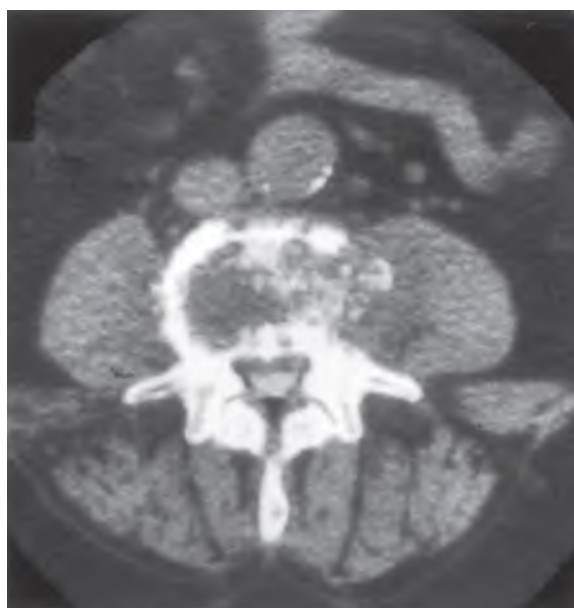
Radiograph of spine showing bone destruction associated with spinal aspergillosis.
